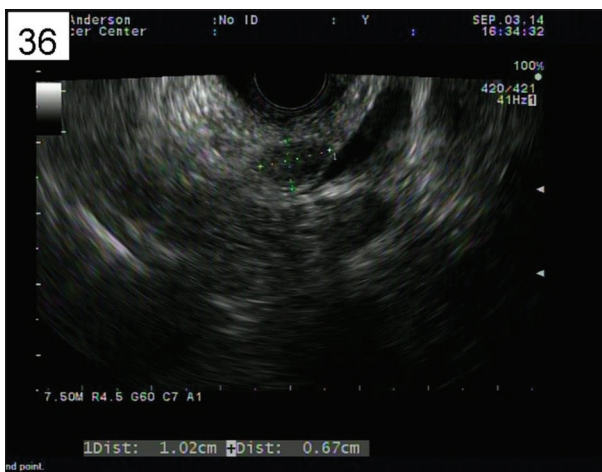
Endoscopic ultrasound image showing oval to rounded, well-defined, hypoechoic nodule measuring 1.02 cm by 0.67 cm size in the mid pancreatic body seen via transduodenal imaging from the duodenal bulb
